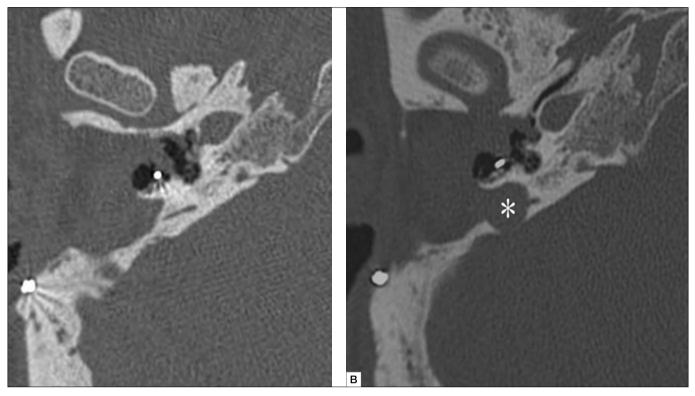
Axial high resolution CT scan, right ear. Patient 5. (A) postoperative scan few months after primary surgery; (B) four years later a round mass with new bone erosion (asterisk) is evident in the same section. Revision surgery confirmed residual cholesteatoma.
